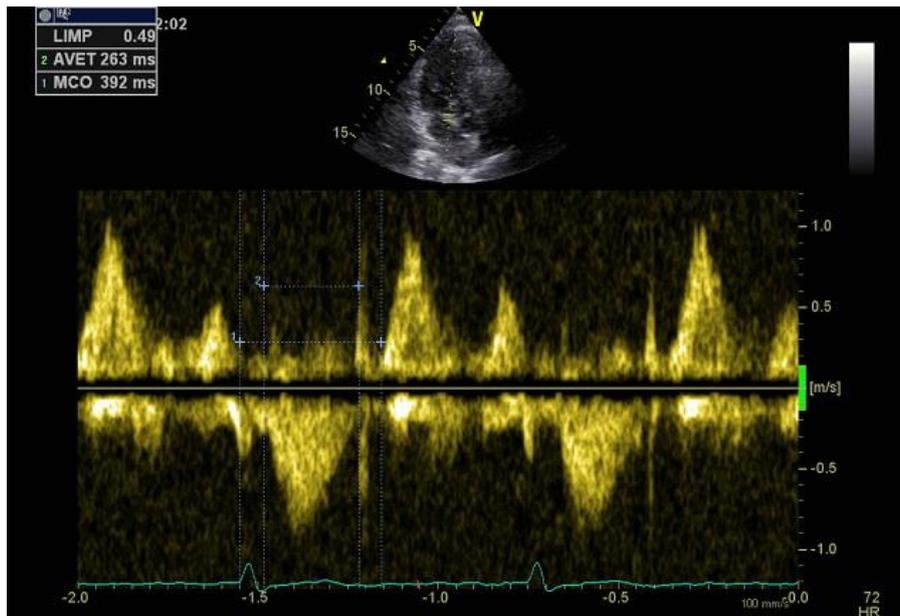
The calculation of Tei index in D-mode of Echocardiography of mitral flow
